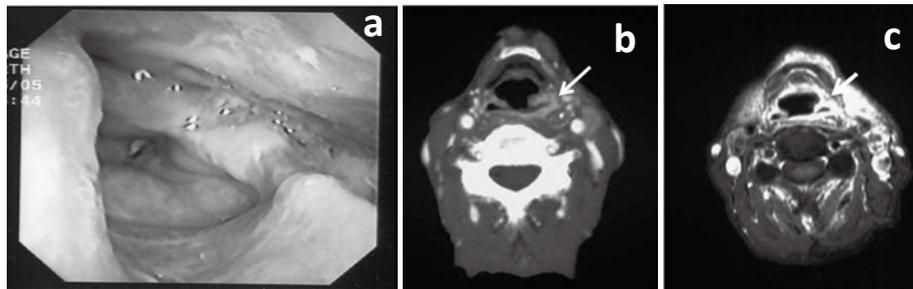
A hypopharyngeal fiberscope (a) reveals mucosal erosion in both arytenoids, the piriform fossa, and posterior wall with left-sided dominance in the hypopharynx. Enhanced CT (b) and MRI (c) reveal mucosal thickening and an enhancement effect (arrow) at the site.
